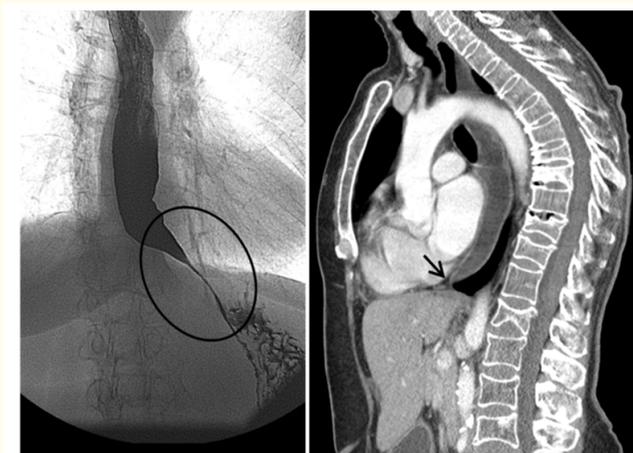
EGD and CT. Esophageal transit in the standing position, an increase in the caliber of the esophagus was observed due to lack of relaxation at the level of the lower esophageal sphincter (circle), suggestive of achalasia. On CT, esophageal dilation was observed until the esophagus-gastric junction where a stenosis was observed "in the beak of a bird" (arrow), findings related to achalasia.
